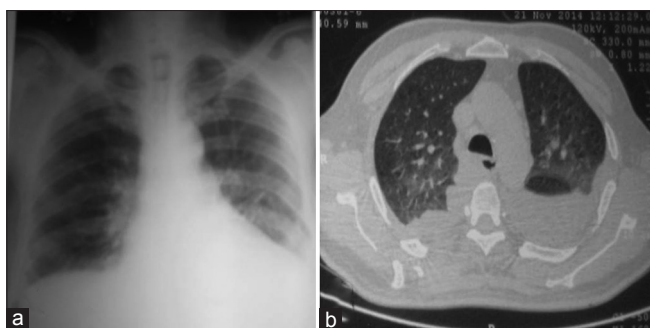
(a) Chest radiograph and (b) computed tomography chest showing resolution of ground glass opacities, interlobular septal thickening, and bilateral effusion
